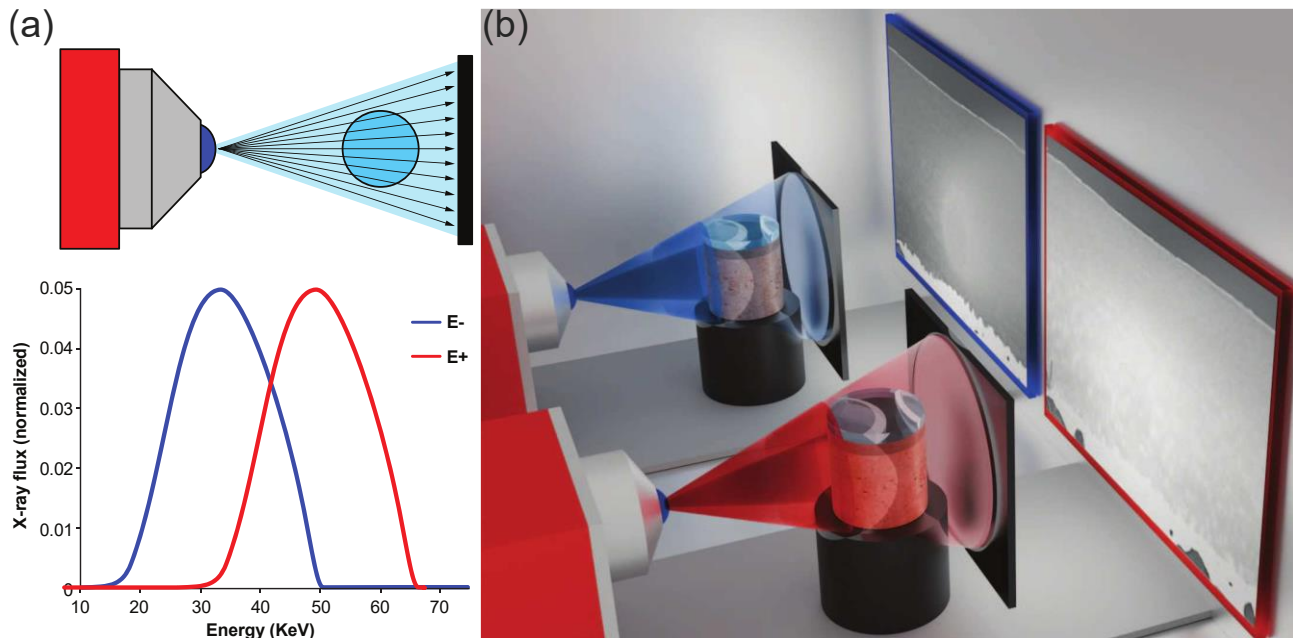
(a) Scheme of DE technique. The procedure includes two distinct X-ray exposures, each at a different beam energy. The low-energy and high-energy components serve as input for decomposition algorithms, to deliver two material maps. (b) Reconstructed section from low-energy E- and high-energy E+ binned photons is reported on blue and red screen, respectively. In the low-energy and high-energy screens are reported sections from reconstructed volume of AC, following the immersion in a gadoteridol/CA4+ mixture. In particular, the contrast in low- and high- energy sections is due mainly to gadoteridol and CA4+, respectively. Images on screens of panel (b) adapted from the work of Honkanen et al. [169], published under Creative Commons license (CC BY 4.0).
